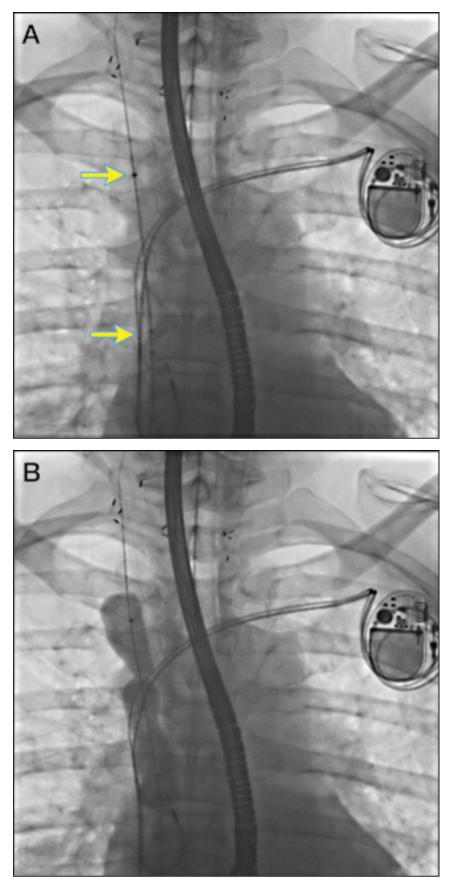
A Bridge Occlusion Balloon (Philips Medical) was placed over a stiff guidewire to cover the potential area of SVC lateral wall injury (Panel A). Diluted contrast is injected into the balloon to confirm adequate placement (Panel B). A marker (sticker) is then placed over the shaft of the catheter when the balloon is in an optimal position. The balloon is then deflated and is pulled down to the level of the IVC. The wire is left in place and serves as a rail to push the balloon up to the marker in an emergency. snare (D Video 1.8). Once tissue contact is made with the femoral sheath, the Goose Neck snare is released and is pulled back on to the shaft of the femoral sheath. Traction with the biopsy forceps and countertraction with the femoral sheath is applied with careful monitoring on echocardiography. A pseudopericardial effusion can be appreciated as the RA wall is pulled away from the pericardial cavity (D Video 1.9). The lead tip was eventually freed and was taken out of the body.
